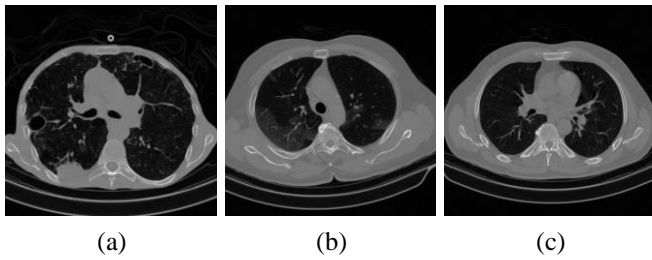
The CT images of lung- a) CAP infected, b) COVID-19 infected, c) Normal
